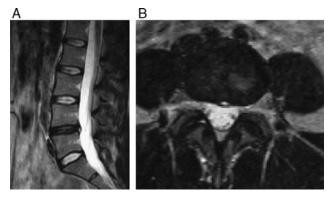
Case 1: Preoperative magnetic resonance imaging; (A) sagittal view showing L4–5 herniated disk, annular tear and disk dessication; (B) axial view showing L4–5 annular tear and central herniation.
